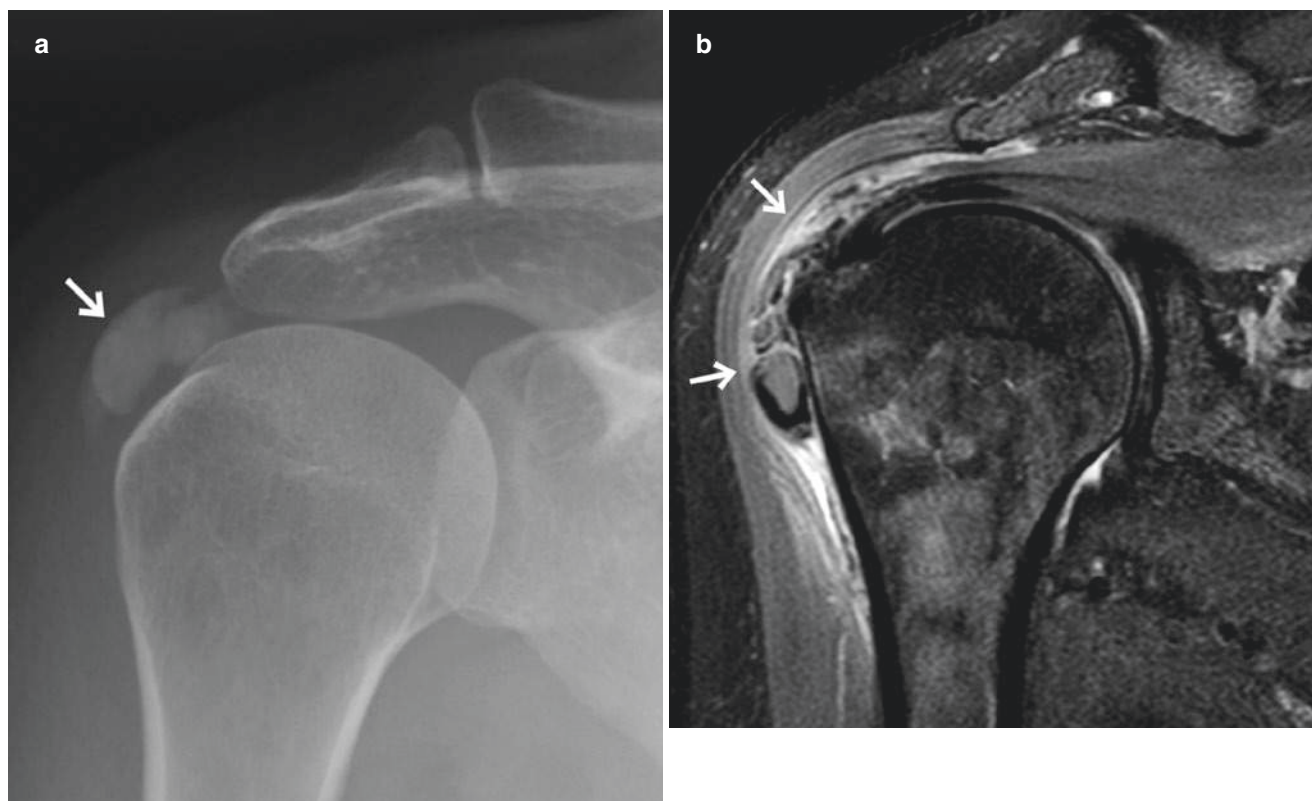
(a) Frontal radiograph of the shoulder showing dense calcification (arrow) in the region of the supraspinatus tendon superficial to greater trochanter. (b) T2-weighted gradient-echo oblique coronal image three
